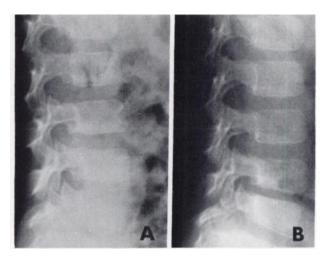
Lateral radiographs of lumbar spine taken at time of admission to hospital (A), and 3 mo later (B). Shrinkage of L4-5 interspace on later radiograph is consistent with diagnosis of disc-space infection.
